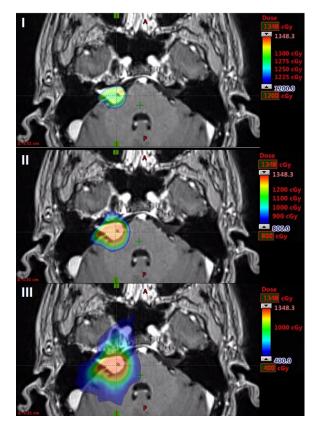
Axial treatment planning CT scan demonstrating the isodose distribution by minimum dose limits of 12 Gy (I), 8 Gy (II), and 4 Gy (III) with corresponding color maps.
